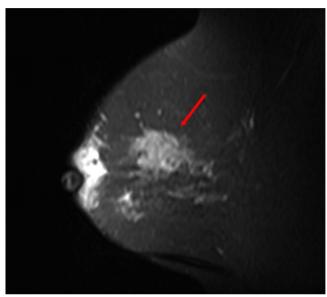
Irregularly shaped lesion (red arrow) in the outer quadrant of the left breast on MRI.
